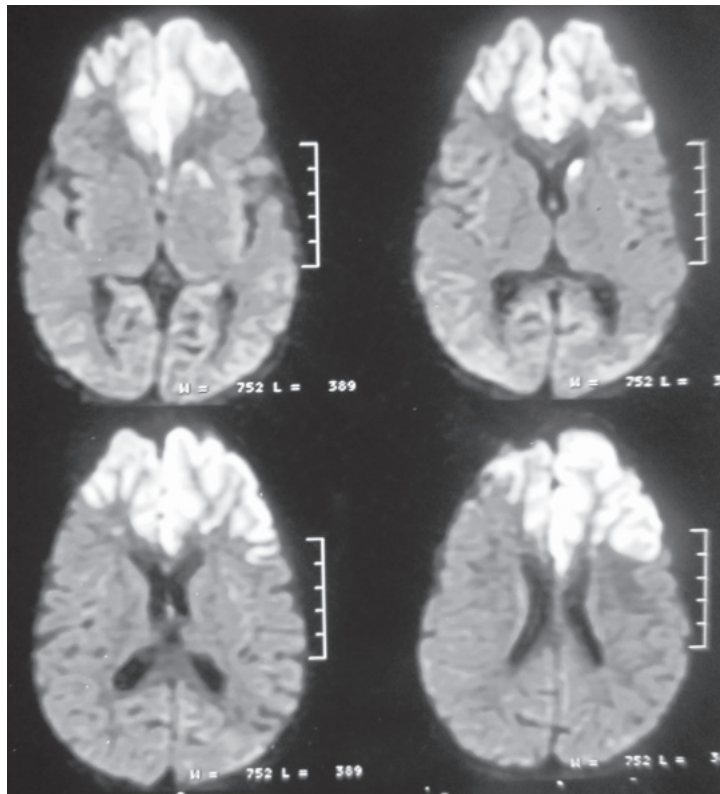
Diffusion weighted MRI demonstrated restricted diffusion in bilateral anterior cerebral and left middle cerebral artery territory suggestive of infarction.
